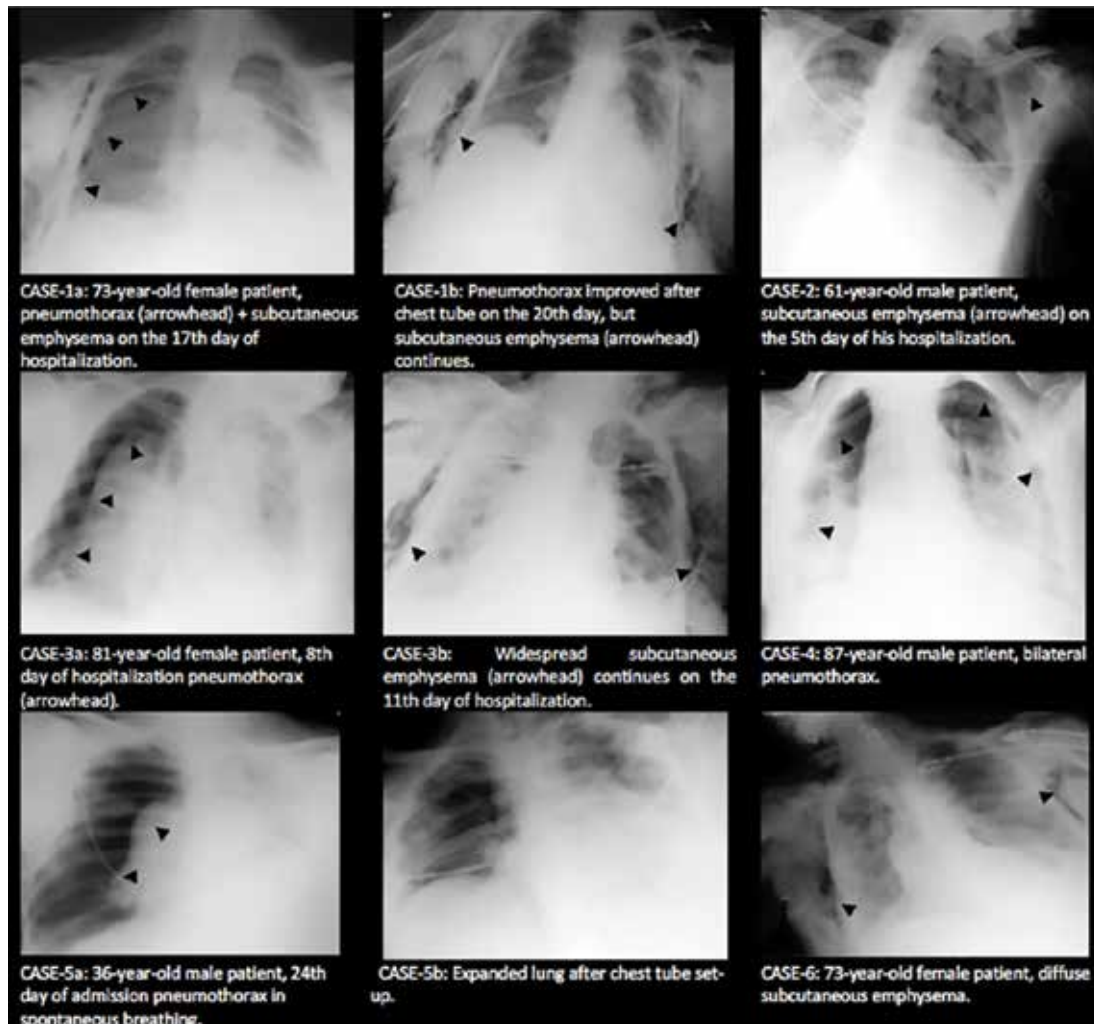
Examples of bedside radiography
